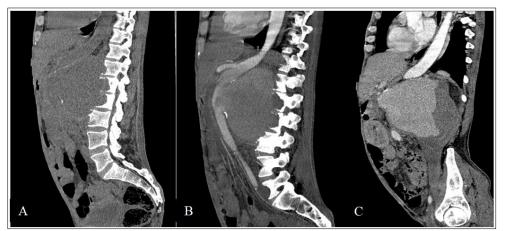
Sagittal reconstruction of abdominal CT without (A) and with contrast (B, C) showing a voluminous saccular aneurysm with circumferential thrombosis
